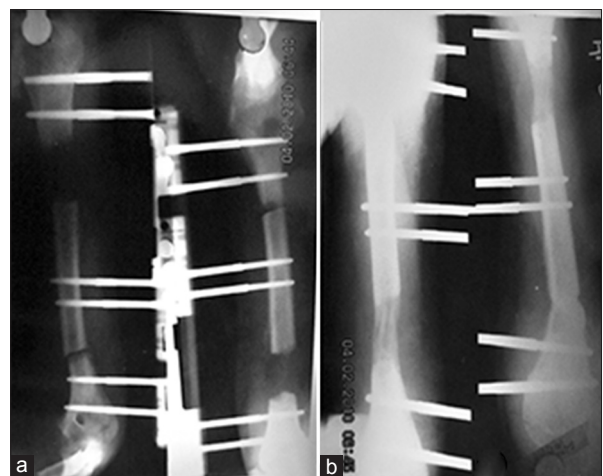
X-ray right arm anteroposterior view showing (a) corticotomy and distraction, (b) regenerate consolidation and docking
